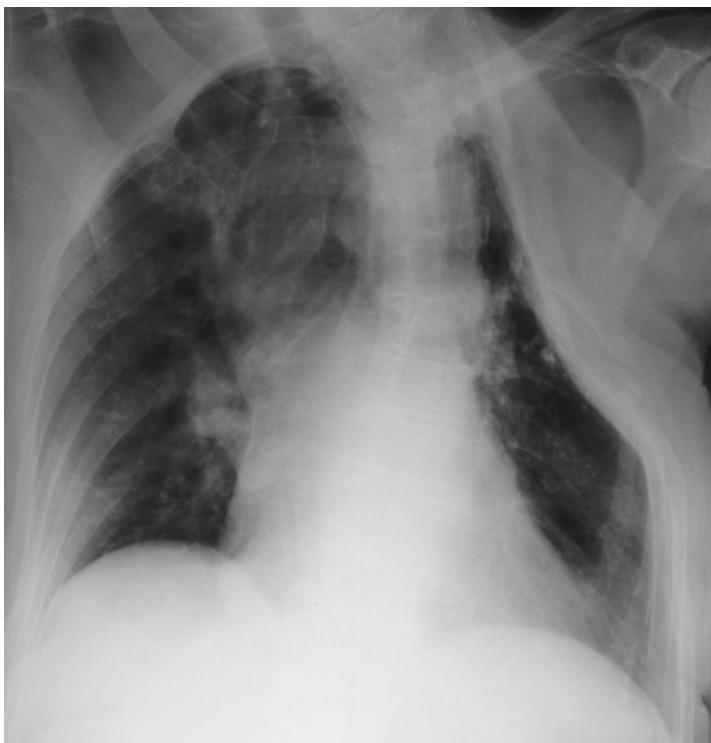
Status post thoracoplasty in pulmonary tuberculosis. The patient is a woman who was 92 years old in 2001 when this preoperative chest radiograph was obtained prior to open reduction of a femoral neck fracture. Severe chest deformity is present following left thoracoplasty. Findings include extensive compression of the upper lobe and rightward upper mediastinal shift. Other findings include moderate senile emphysema with tracheobronchopathia calcarea and signs of pulmonary arterial hypertension. Heart size is normal. There is no infiltrate.
